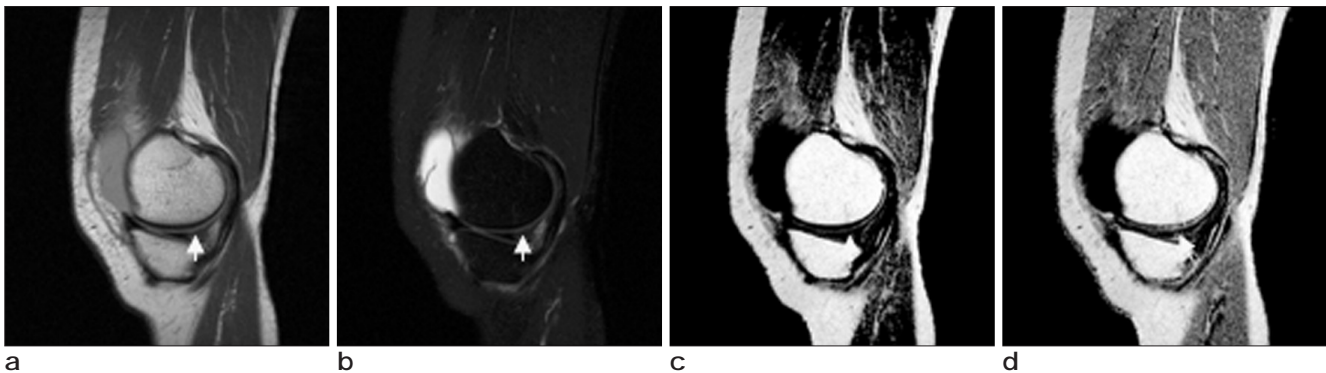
(a) Sagittal spin echo proton density obtained from 56 year-old female. TR 2000 ms, TE 35 ms, NEX 3, Echo Train Length 3, and (b) fat suppressed T2-weighted image obtained from TR 3418.67 ms, TE 90ms, NEX 2, ETL 11. Anterior cruciate ligament shows increased signal intensity, indicating tear (arrow). (c) MTR image of bins 1% with threshold intensity; 120. (d) MTR image of bins 0.1% with threshold intensity; 150.
